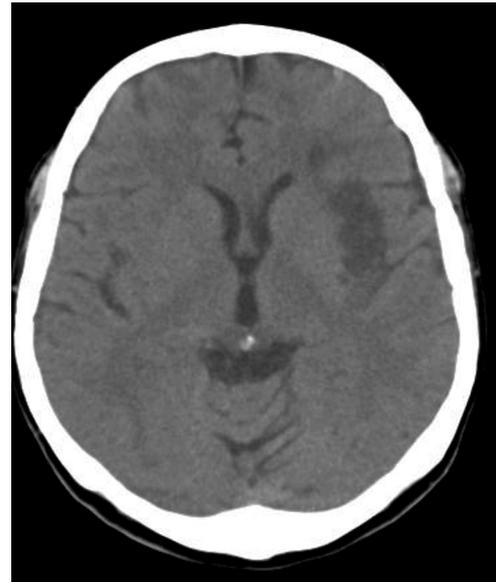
Ischemic stroke in fronto-temporal lobe (by computed tomography scan) in patients with pure agraphia*
